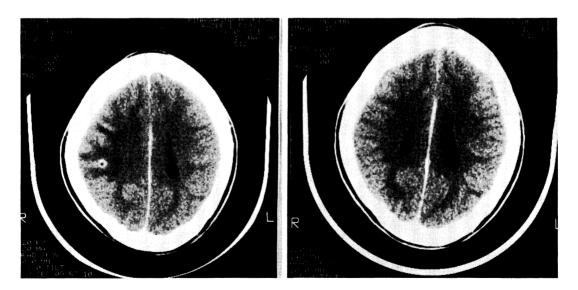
Fig —Left, contrast computed tomographic (CT) scan before treatment (patient no. 12) shows a ring enhancement with perilesional edema. Right, 3 months after treatment CT scan shows disappearance of the lesion.
